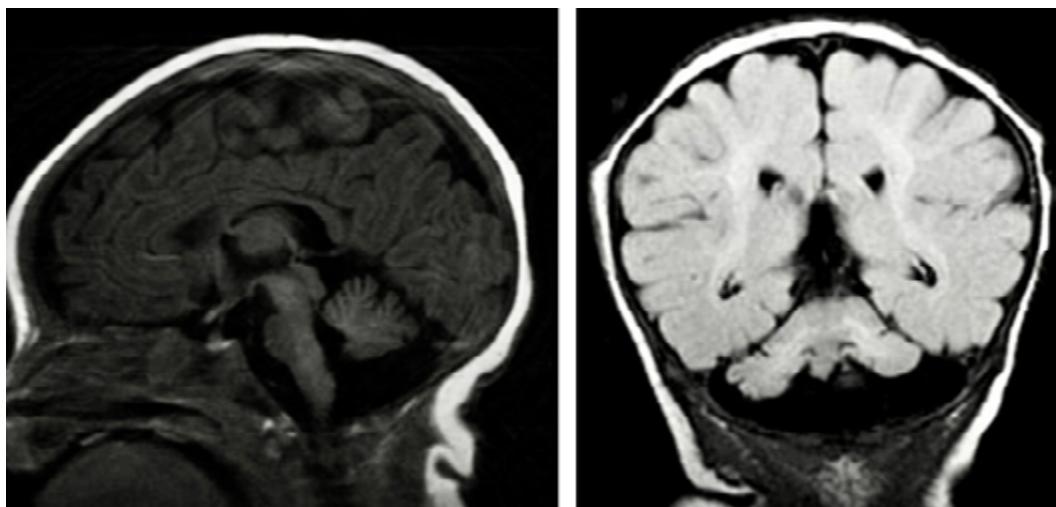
Brain MRI showing cerebellar vermic atrophy. A) Sagittal plane / T1 sequence; B) Coronal plane / FLAIR sequence.
